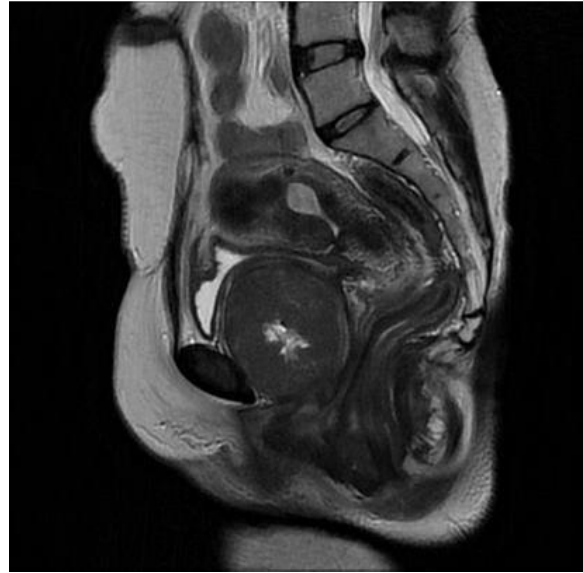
MRI imaging showing leiomyoma anterior to the cervix and anterior vaginal wall
